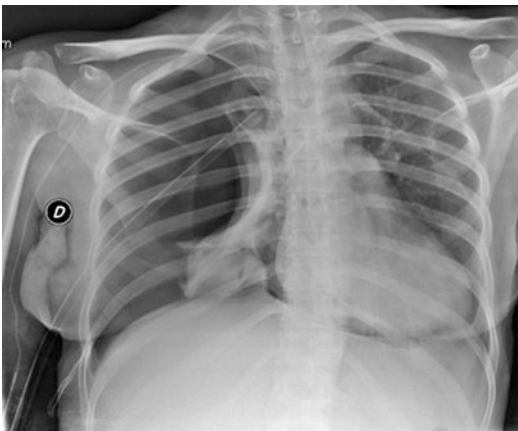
Chest radiograph shows a right undertension pneumothorax. Right lung is seen to be collapsed below the hilus (fallen lung sign). A pleural tube has been inserted on the right
